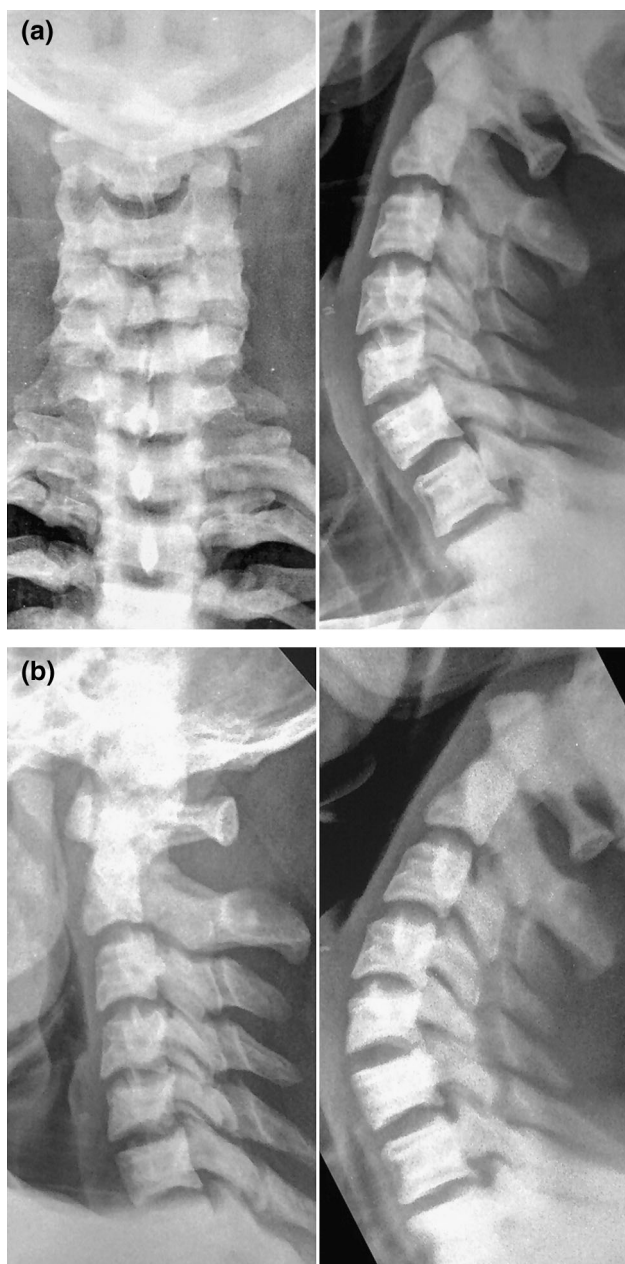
Follow-up X-rays at 18 months after injury a antero-posterior and lateral, b flexion and extension views
